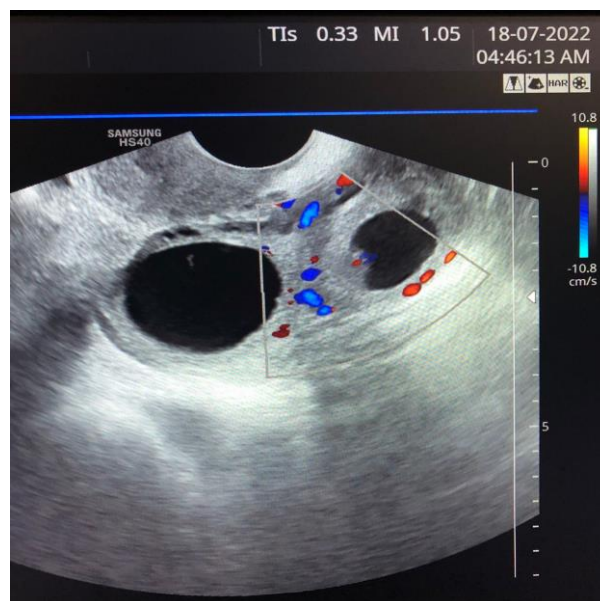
the transvaginal ultrasonography (TVS) results indicate the presence of a gestational cyst with a fetal pole in adnexal area (in left).
